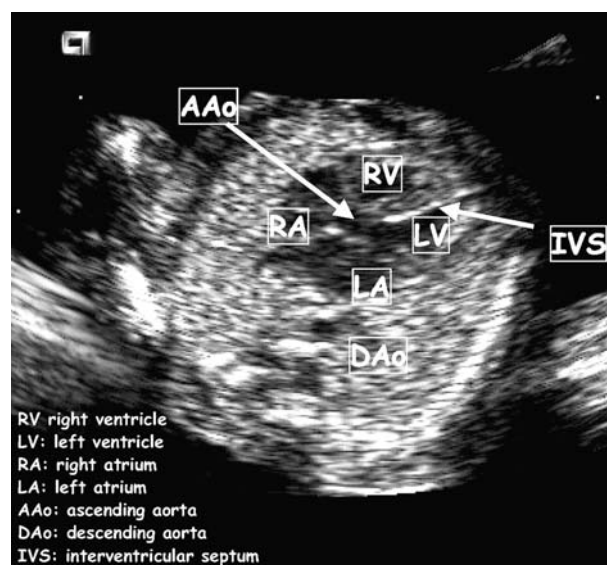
Early fetal echocardiography by 2D in a structurally normal heart. The five-chamber view: left ventricle outflow tract in the long axis view showing the continuity between the interventricular septum and the anterior wall of the ascending aorta.
